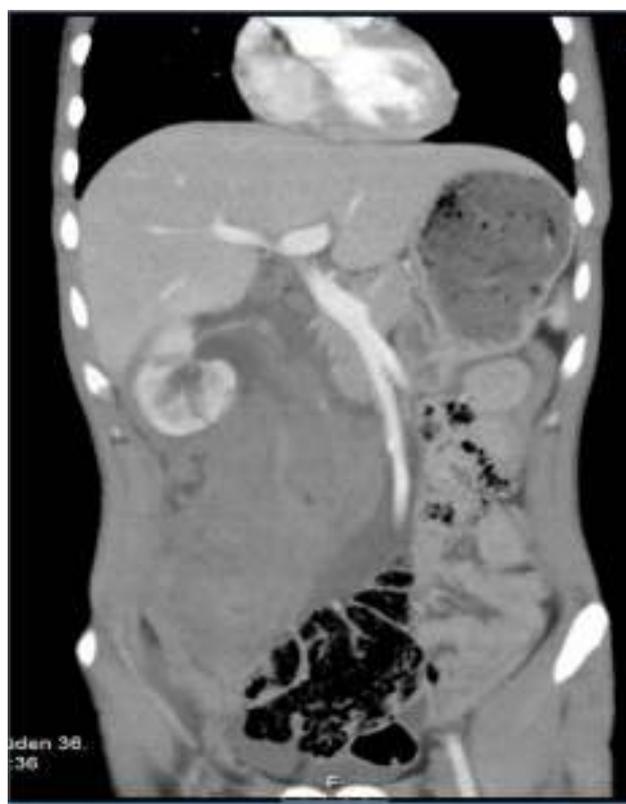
Perirenal Hemorrhage CT Image 2
